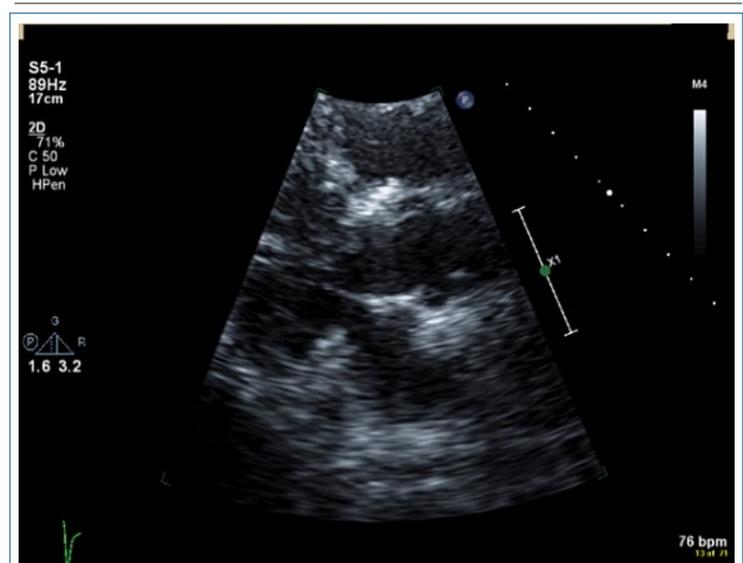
Parasternal Long Axis View of Anterior Leaflet of Mitral Valve Across the LVOT in Systole (arrow). Note that the aortic valve is opened in systole.
